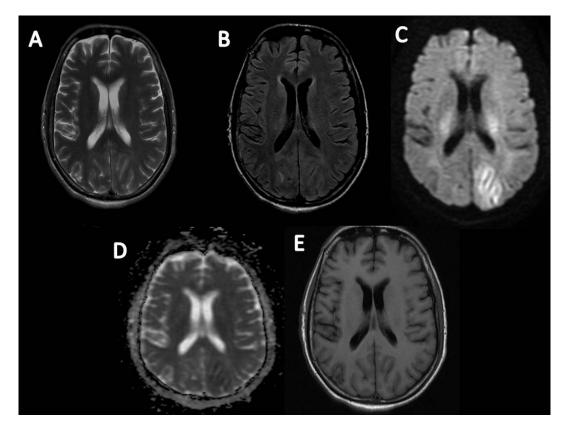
Axial T2(Fig. A)/FLAIR (Fig. -B) sequences reveals ill-defined areas of asymmetrical hyperintensities in bilateral parieto-occipital lobe. On DWI (Fig. C) gyri form pattern of restriction seen on left side appearing bright and corresponding region on ADC (Fig. D) appear dark. On T1 weighted sequence(Fig. -E) altered area appear isointense
